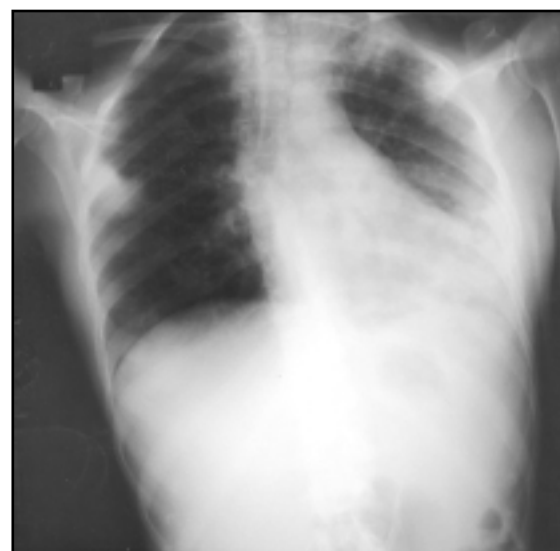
Chest x-ray after 4 weeks' treatment with doxycycline – shadowing is increased in the left mid and lower zones, and there is new peripheral shadowing in the right midzone.
